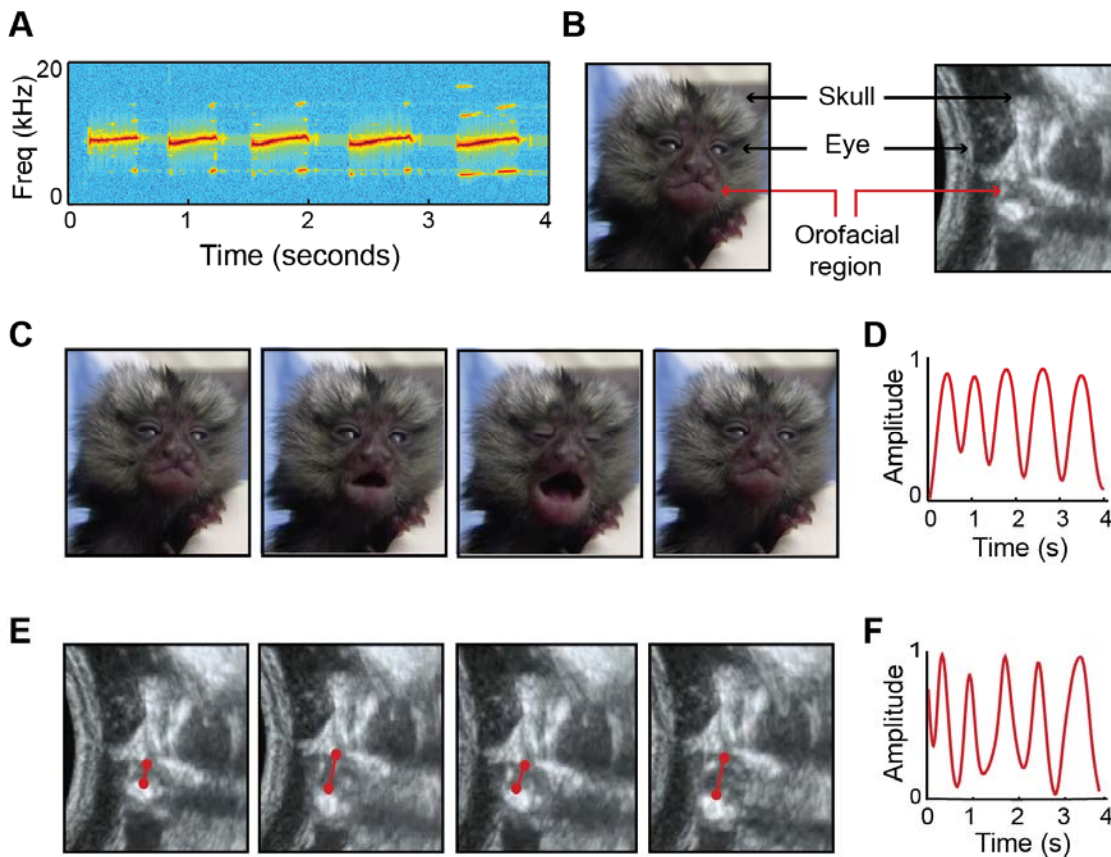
Signature features of marmoset infant calls observed in fetal movements. (A) Spectrogram of a five-syllable infant contact call from postnatal week 1. (B) Stills of marmoset infant and fetus, indicating orofacial region (C) Video stills of week 1 infant producing a five-syllable contact call. (D) Temporal profile of the infant contact call in (C), generated by tracking orofacial movements. (E) Ultrasound stills of the orofacial movements of a late-stage marmoset fetus. (F) Temporal profile of the fetal orofacial movements in (E). The match between infant and fetal orofacial movements can be observed in video S3.
